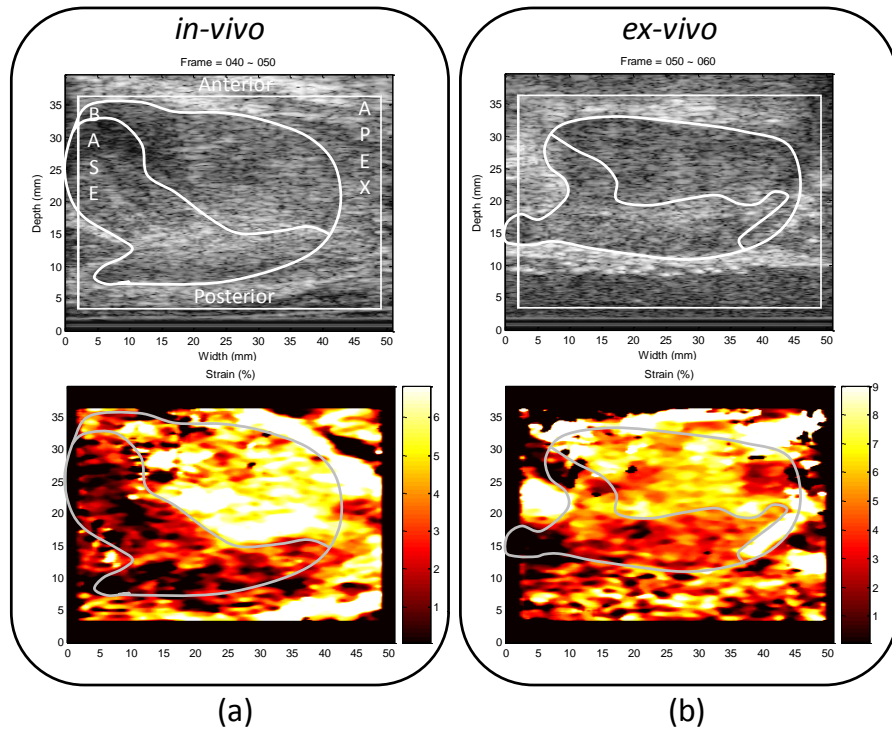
Prostate ultrasound and elasticity images of (a) *in-vivo* and (b) *ex-vivo* examination (case #5). Outlines on images are manually drawn based on ultrasound and elasticity imaging results.
